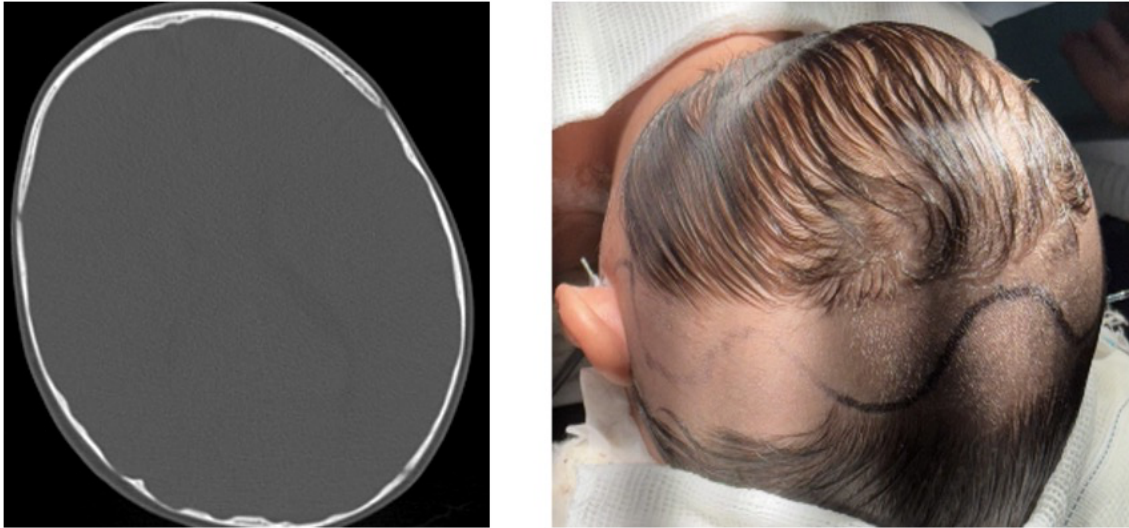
Deformity of the right occipital bone before surgical approach. Left, density reduction of the occipital bone evidenced by CT scan. Right, posterior right side skull depression prior to surgical management
